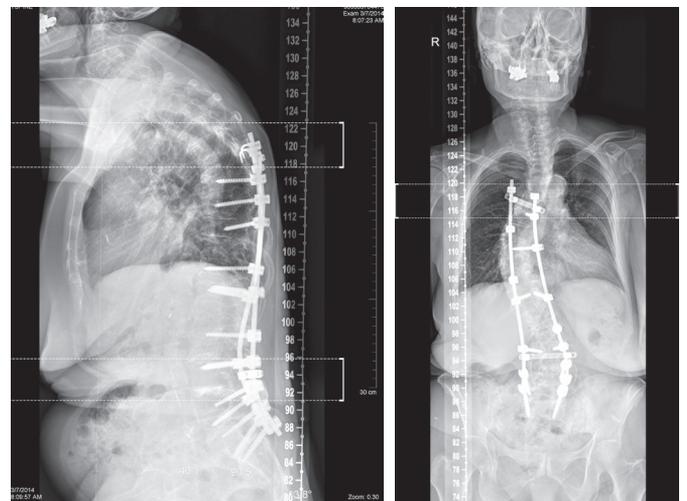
Preoperative standing lateral view X-Ray. Figure 3. Preop. standing anteroposterior view X-Ray.
